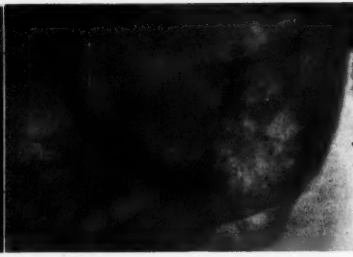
Roentgenogram of the temporal bone, after the Stenvers method. Acumination of the apex of the pyramid due to increase of the endocranial pressure.
